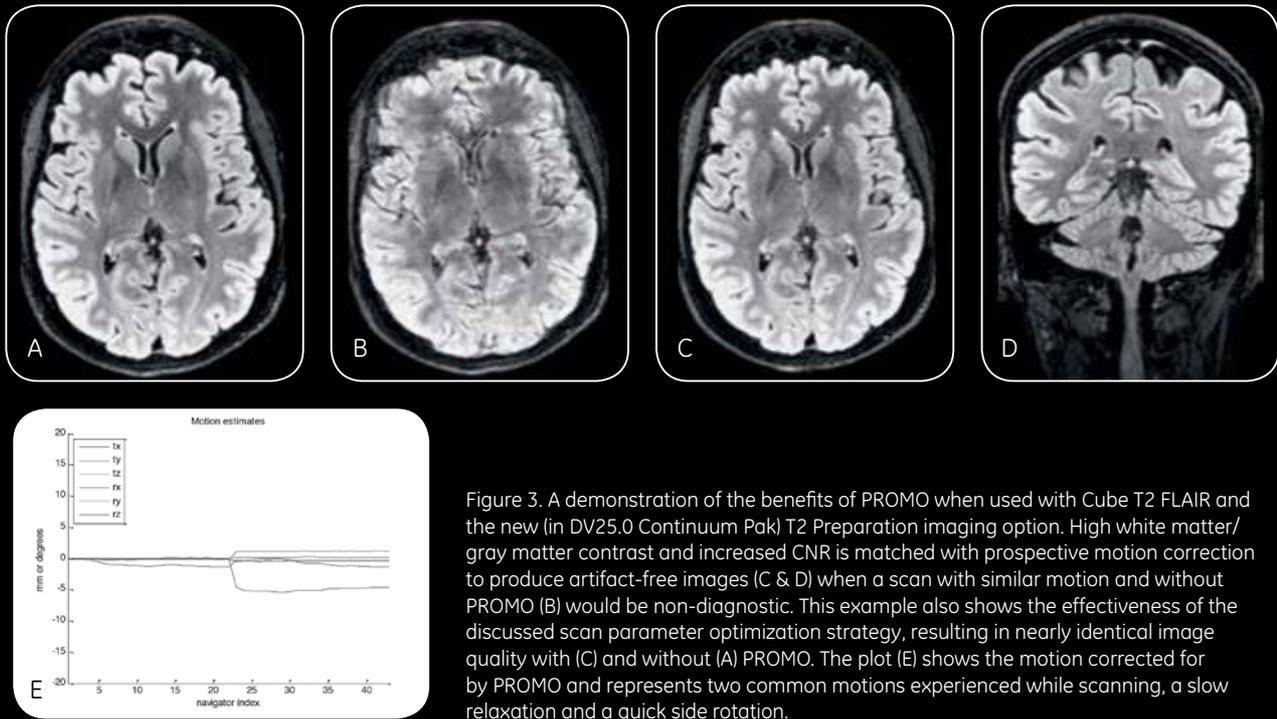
A demonstration of the benefits of PROMO when used with Cube T2 FLAIR and the new (in DV25.0 Continuum Pak) T2 Preparation imaging option. High white matter/gray matter contrast and increased CNR is matched with prospective motion correction to produce artifact-free images (C & D) when a scan with similar motion and without PROMO (B) would be non-diagnostic. This example also shows the effectiveness of the discussed scan parameter optimization strategy, resulting in nearly identical image quality with (C) and without (A) PROMO. The plot (E) shows the motion corrected for by PROMO and represents two common motions experienced while scanning, a slow relaxation and a quick side rotation.
